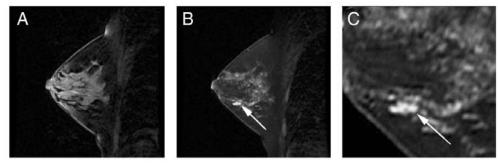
Magnetic resonance image of a 46-year-old woman at high risk for developing breast cancer: A. sagittal precontrast T2-weighted; B. postcontrast T1-weighted; and C. magnified view of 8x13x3 linear focus of enhancement in the left breast (arrows). Lesion was negative on screening mammography and ultrasound. Pathology confirmed invasive ductal carcinoma. Lehman C, Schnall MD. Imaging in breast cancer: magnetic resonance imaging. Breast Cancer Res. 2005;7(5):215-219.
